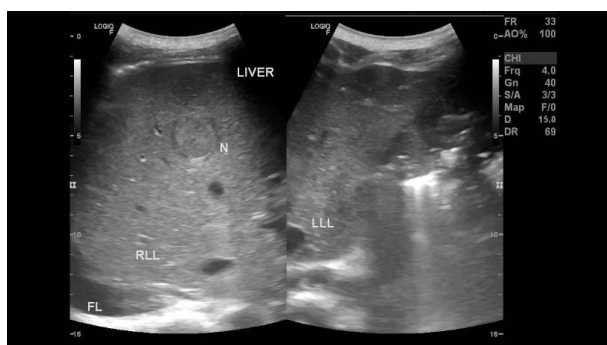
The results of an abdominal ultrasound show multiple nodules in the liver
